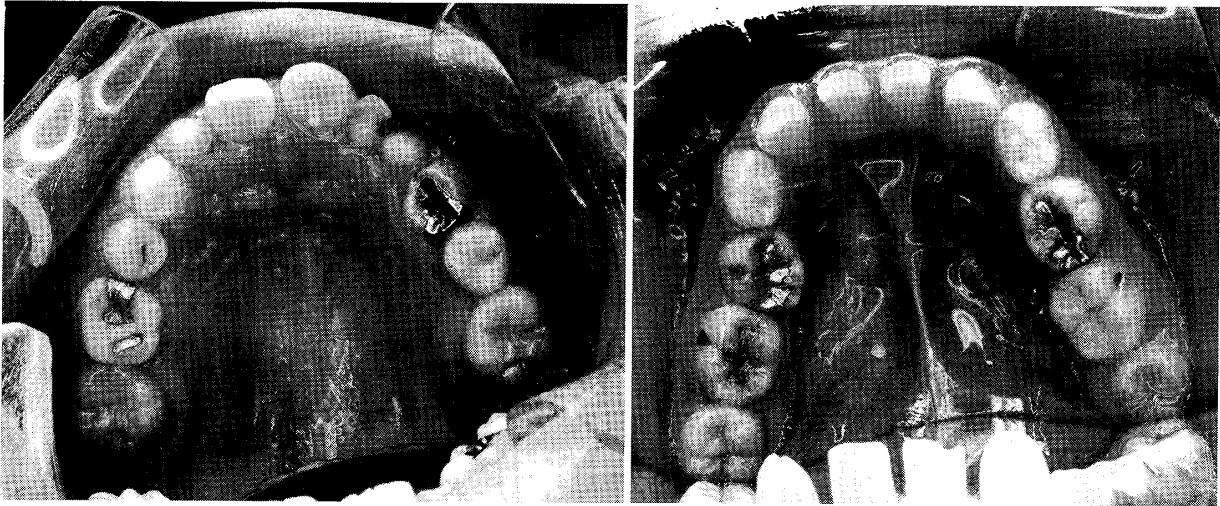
A representative case of the oral findings of Williams syndrome (Case 13) It shows congenitally missing teeth ($\frac{53}{542} \frac{34}{245}$), and microdontia ($\frac{42}{2}$). (Congenitally missing teeth were confirmed by radiographic findings.)
